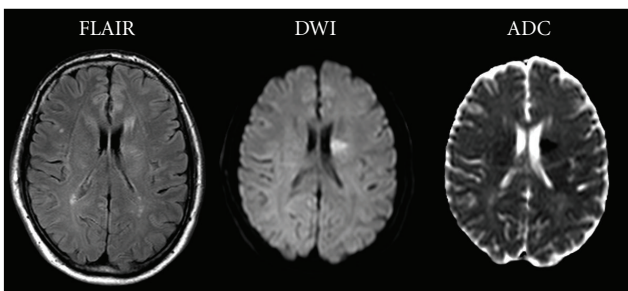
Case 3: Follow-up MRI with FLAIR, DWI and ADC showing a small lacunar infarction in the right corona radiata that is also seen retrospectively on the CTP maps (Figure 7).
